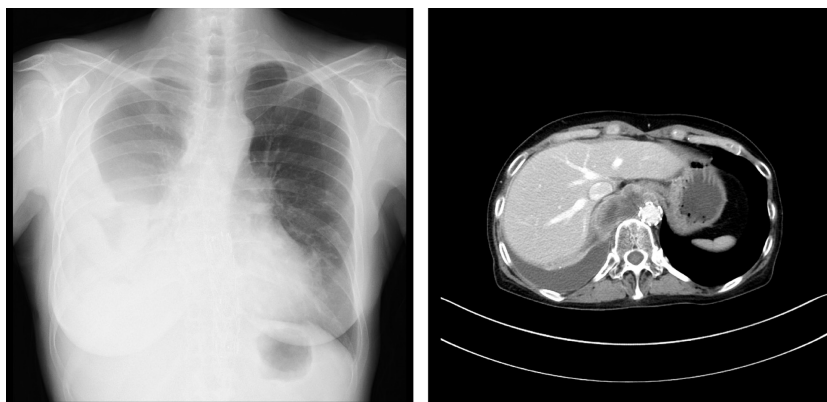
Chest X-ray and CT scan before treatment with ceritinib.
